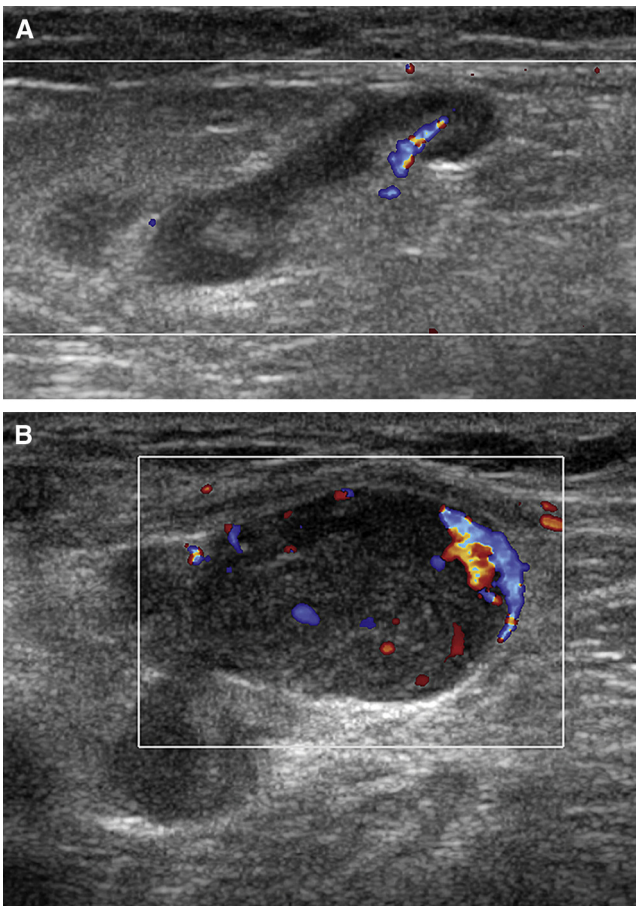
(A) Reactive inguinal lymph nodes; transverse sonogram with colour-Doppler imaging, showing an oval-shaped hypoechoic nodule with fatty hilum and vascularity; the cortex is smooth and thin; the features are compatible with a reactive lymph node. (B) Malignant inguinal lymph node; transverse sonogram with colour-Doppler imaging, demonstrating an abnormally enlarged rounded lymph node with loss of the normal fatty hilum; peripheral vascularity with a chaotic pattern is seen in the lymph node; percutaneous biopsy yielded material consistent with a lymphoma. This figure is available in colour online at <http://carjonline.org/>.
